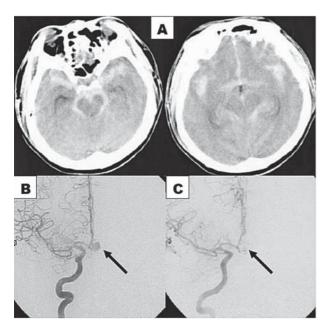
(A) A nonenhanced CT scan of the brain revealed SAH and hydrocephalus. (B) A digital subtraction angiography of the right internal carotid artery showed a saccular aneurysm (arrow) arising from the anterior communicating artery, which measured 7.1×8.2 mm. (C) A postcoiling angiography showed disappearance of the aneurysm.
